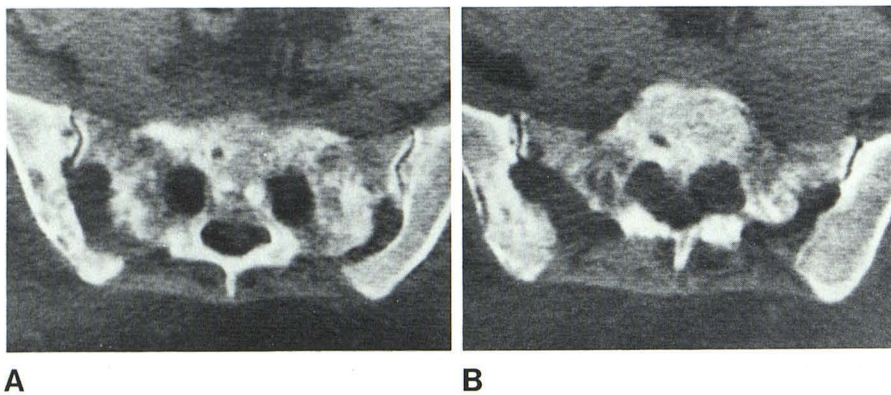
Lymphosarcoma. CT of sacrum shows destruction of sacrum and iliac bone (A) with large ventral soft-tissue components bilaterally (B).
